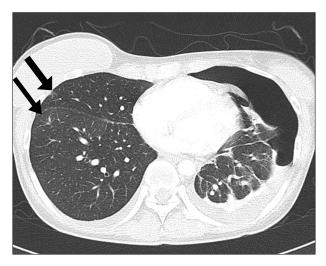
Chest computed tomography scans of patient 1. A thick arrow indicates the cavitary nodule in the right middle lobe. A thin arrow shows a linear opacity in the right lower lobe. On the left side, a moderate amount of pneumothorax with pleural effusion was noted.
